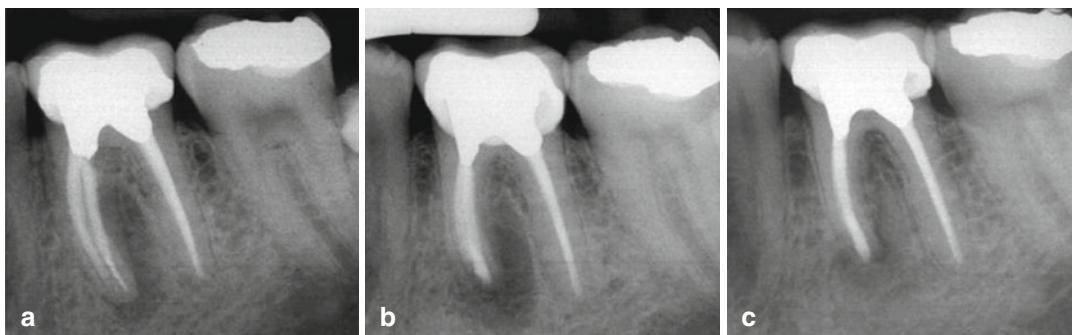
Radiographical follow-up of first mandibular molar with a separated file in the mesial root. The patient has acute infection following the completed root canal
